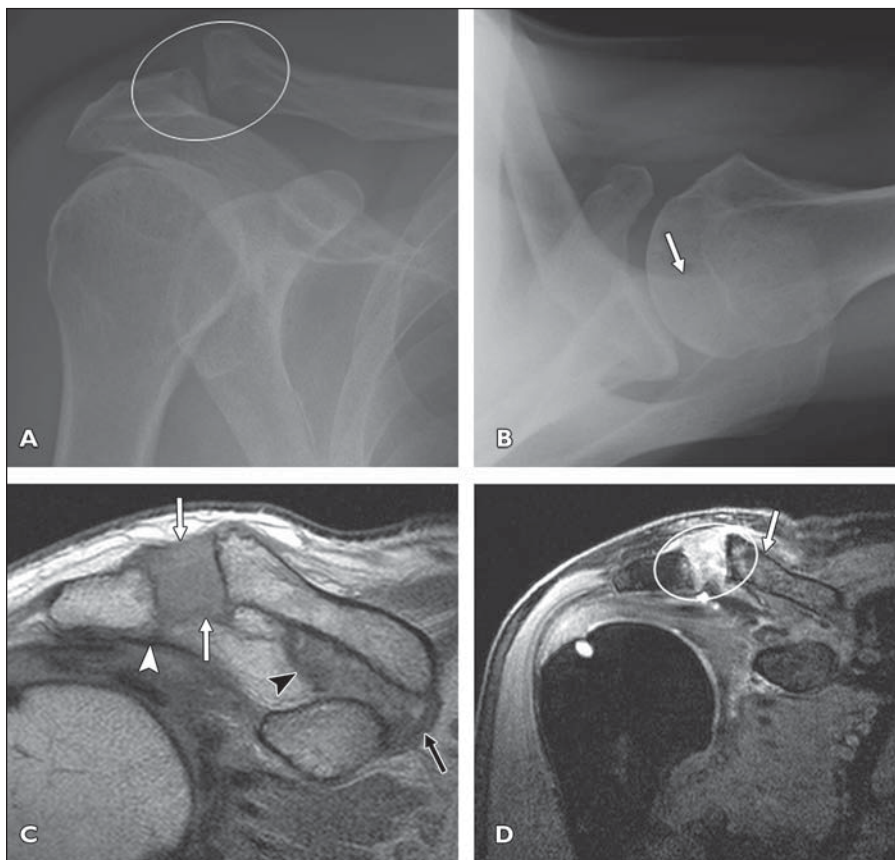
52-year-old man after right-sided acromioclavicular joint injury with suspected radiographic Rockwood type IV injury reclassified Rockwood type III at MRI. A, Anteroposterior radiograph shows 50% superior displacement of clavicle (*ellipse*). B, Radiograph in axial shoulder projection shows apparent posterior displacement of clavicle (*arrow*). C, Coronal proton density-weighted image (TR/TE, 1500/25) shows disruption of superior and inferior acromioclavicular (*white arrows*), conoid (*black arrowhead*), and trapezoid (*black arrow*) ligaments, diffuse abnormal changes in signal intensity, and ligamentous soft-tissue swelling. Undisrupted coracoacromial ligament is below this plane and only partially visible (*white arrowhead*). D, Coronal T1-weighted water-selective MR image shows bone bruise of distal clavicle (*arrow*) and diffuse acromioclavicular joint edema (*ellipse*).
